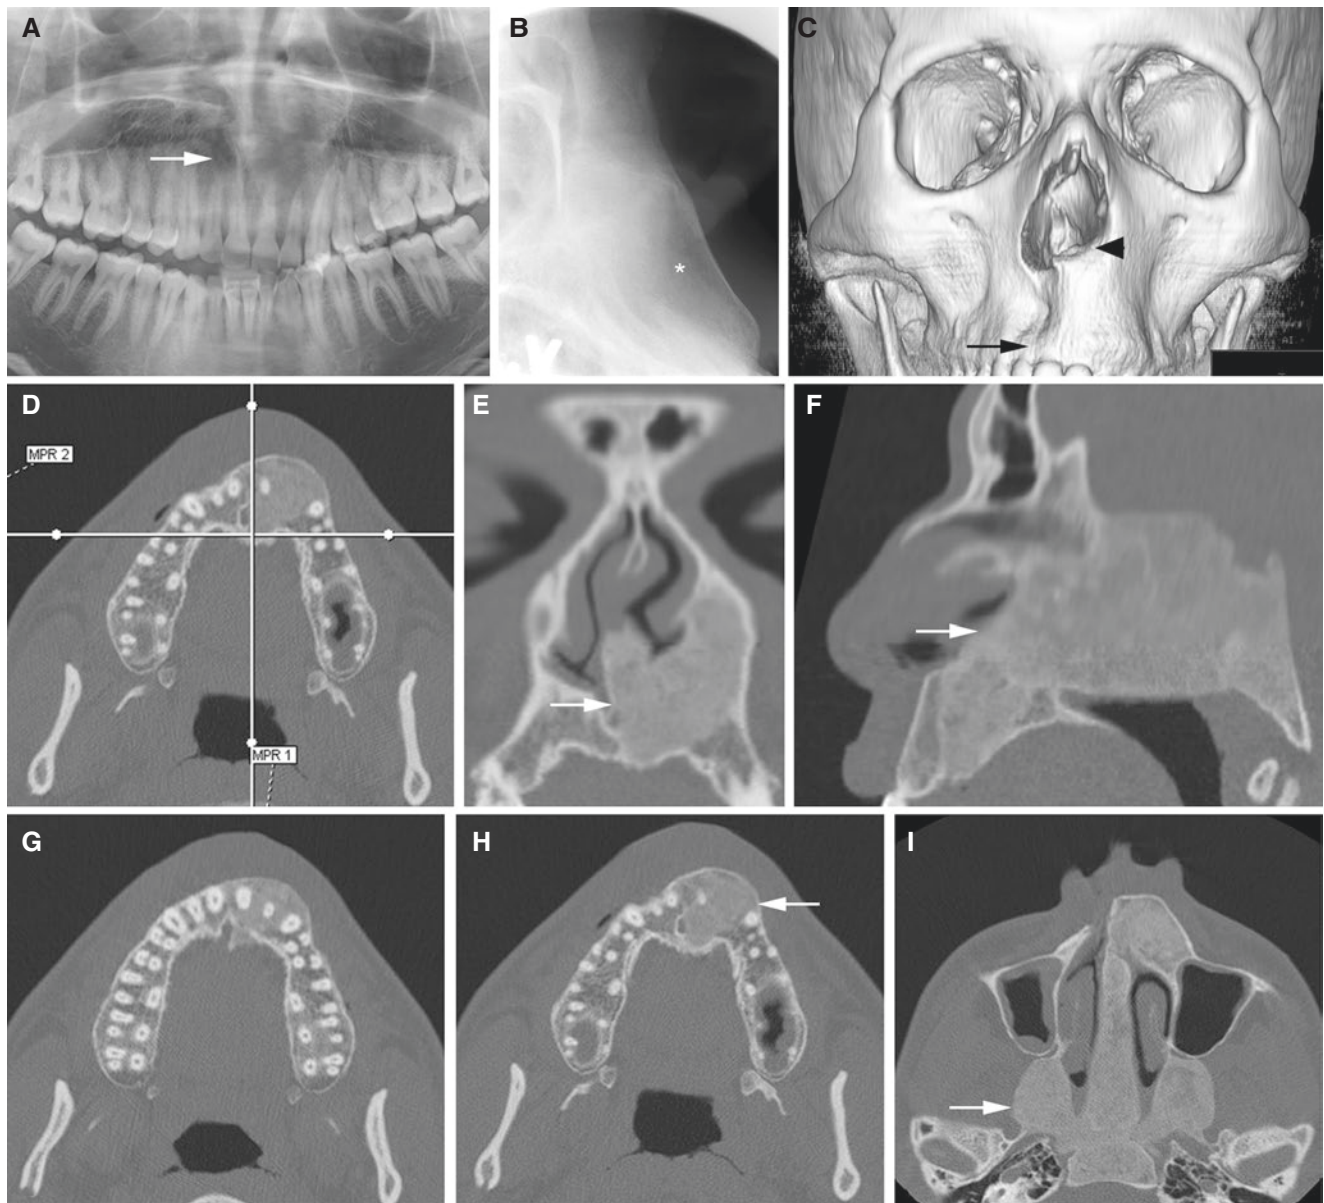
Fibrous dysplasia, maxilla; 18-year-old male with painless and firm swelling in the anterior part of the maxilla. (A) Panoramic view shows diffuse area in maxillary front (*arrow*). (B) Occlusal (tangential) view shows ground-glass appearance of bone (*asterisk*). (C) 3D CT image shows nasal cavity deformity (*arrowhead*) and buccal
